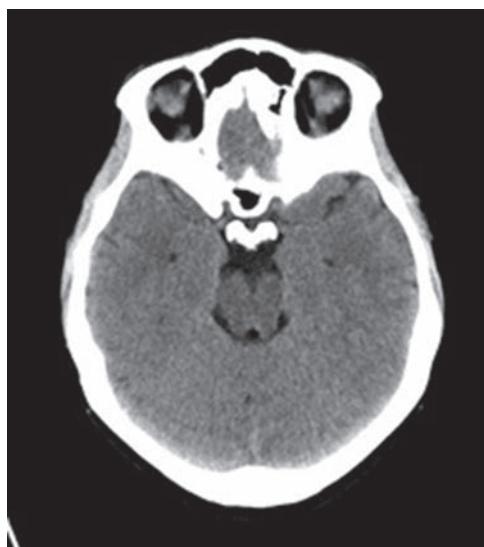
Brain CT scan of a human
